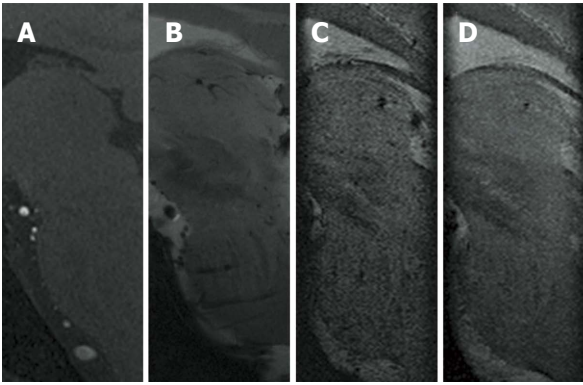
Representative enlarged visualization of the zona incerta in sagittal view. A: T1-weighted gradient-echo sagittal; B: FLASH2D-T2Star sagittal; C: Susceptibility-weighted imaging (SWI) sagittal; D: SWI-minimum intensity projections sagittal.
